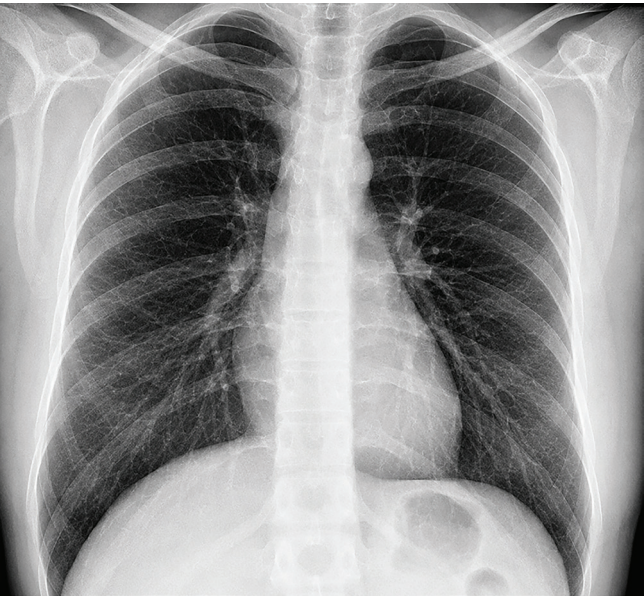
Posteroanterior chest radiograph showed no apparent abnormalities
